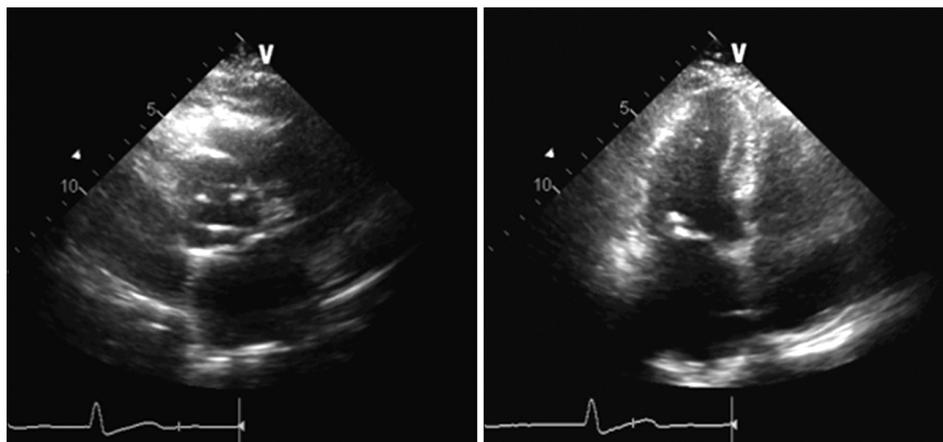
Follow-up transthoracic echocardiography after surgery showed no remnant mass lesion in the left atrium.
